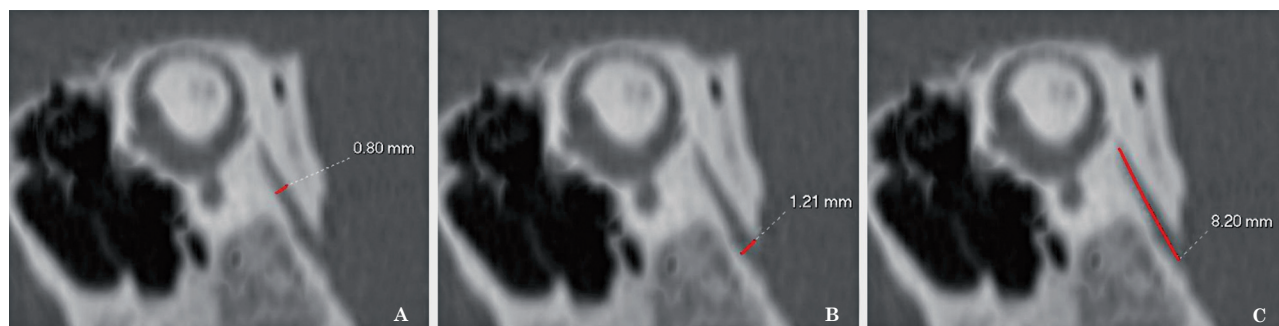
MPR CT images reformatted on Pöschl's plane with measurements of the vestibular aqueduct. A) VA width measured at the midpoint between external aperture and common crus; B) external aperture width; C) VA length.
